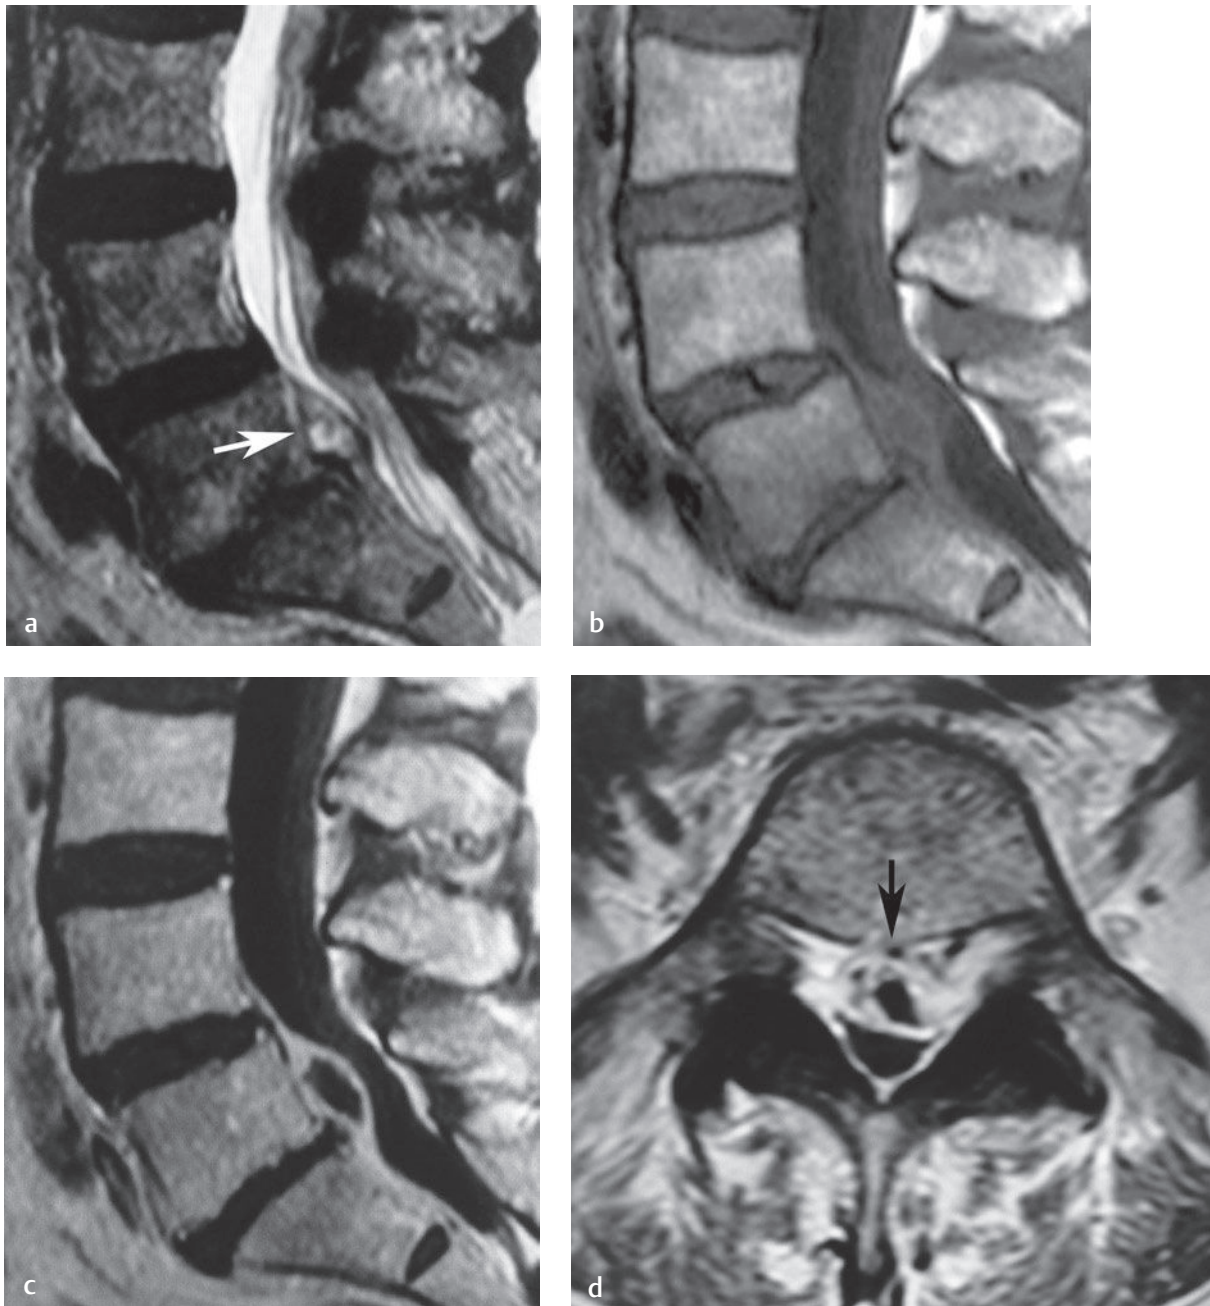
Epidural abscess. (a) A sagittal T2-weighted image shows a ventral epidural collection (*arrow*) posterior to the L5 vertebral body in a patient with infectious symptoms and findings. (b) A sagittal T1-weighted image shows the same collection. (c) A sagittal postgadolinium T1-weighted image shows peripheral enhancement. (d) An axial postgadolinium T1-weighted image shows the ventral epidural collection (*arrow*), again with peripheral enhancement; the abscess is producing moderate to severe stenosis.[†]
